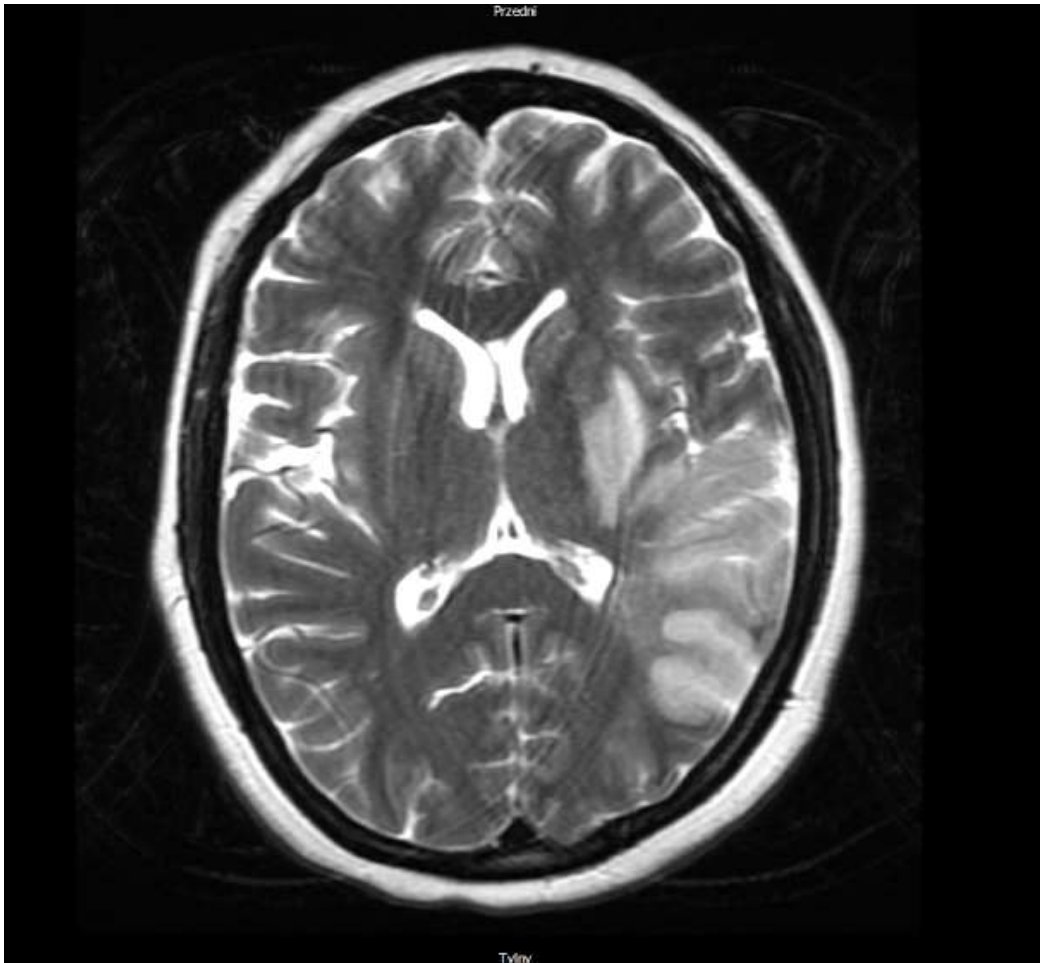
CT of the head (T2-weighted scan) – within the temporal lobe / basal ganglia on the left side hyperintensive areas with diffusion restriction are visible (40x75 mm) [authors' material]
